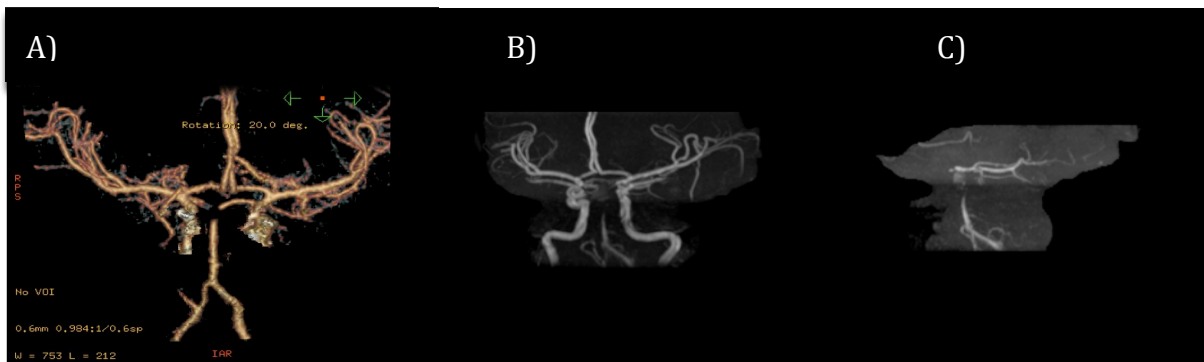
A) CT Angiogram, B) Anterior View MRA, and C) Lateral View MRA Showing Basilar Tip Occlusion
